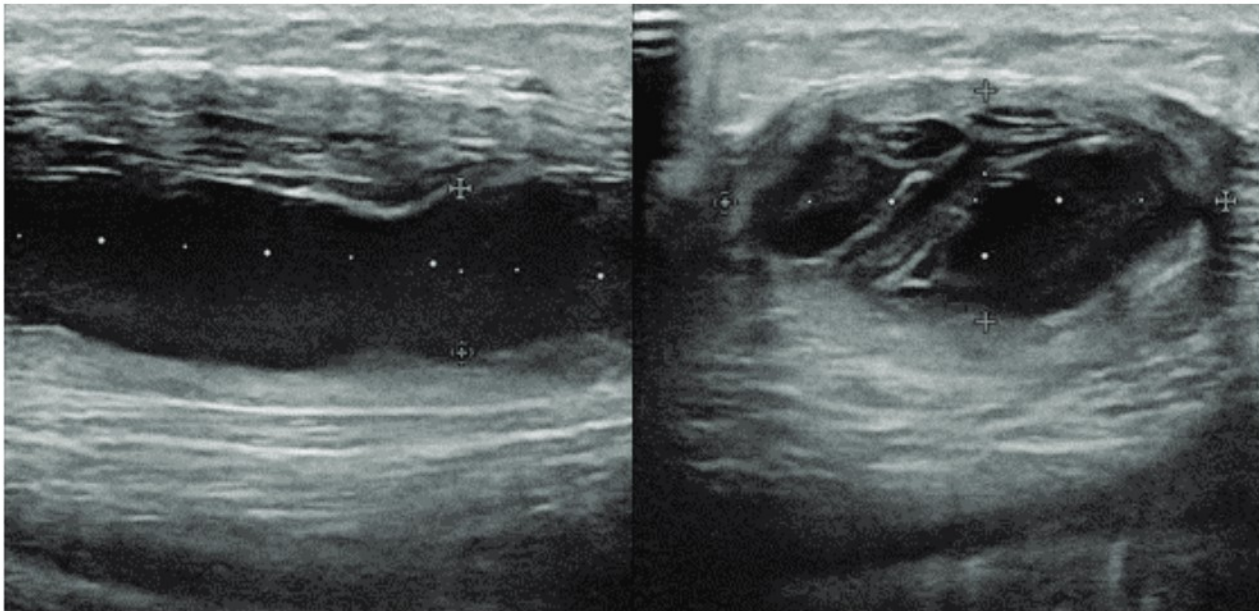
Two months after surgical intervention, ultrasound images showed a collection of likely serum hematic content of a very small size compared to the previous evaluation and bounded by thick fibrous tissue.
